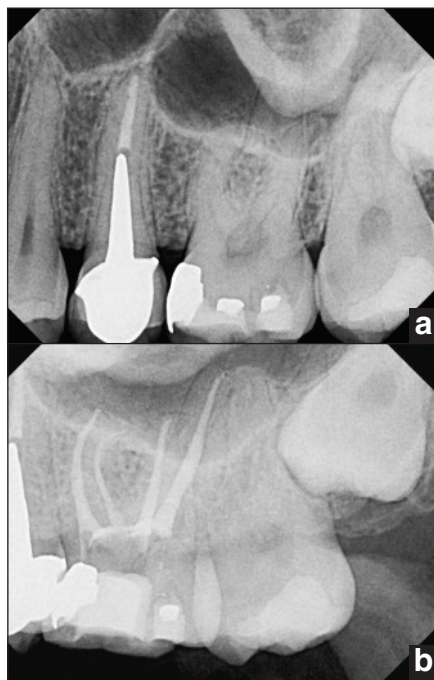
Pre- and post-op radiographs of a maxillary molar with .04 tapers and BC Sealer. Courtesy of Dr. Ali Nasseh, Boston.
